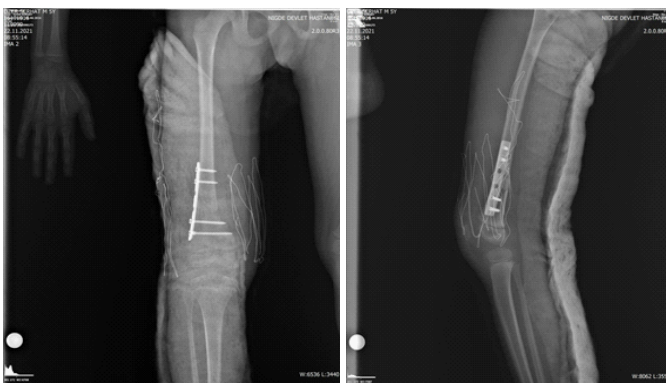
Postoperative direct radiography images of the patient.
